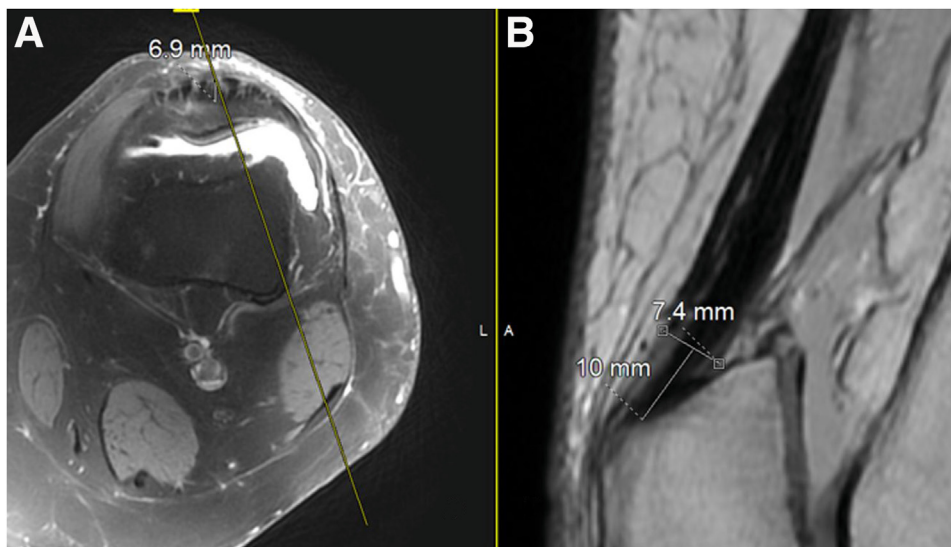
Proton density fat-suppressed axial (A) and proton density non-fat-suppressed sagittal (B) magnetic resonance images in a left knee depicting the method for measuring the thickness of the quadriceps tendon at 1 cm from the proximal patella in both the axial and sagittal planes.
